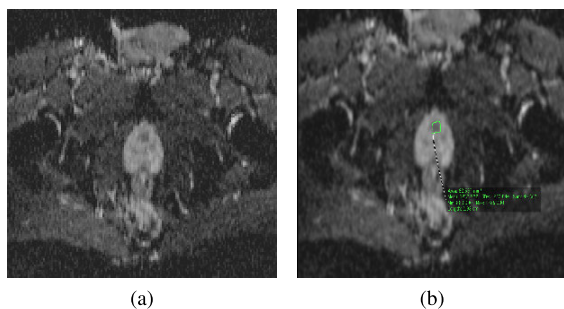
Diffused Weighted T2W MRI in (a) and its ADC map in (b).
